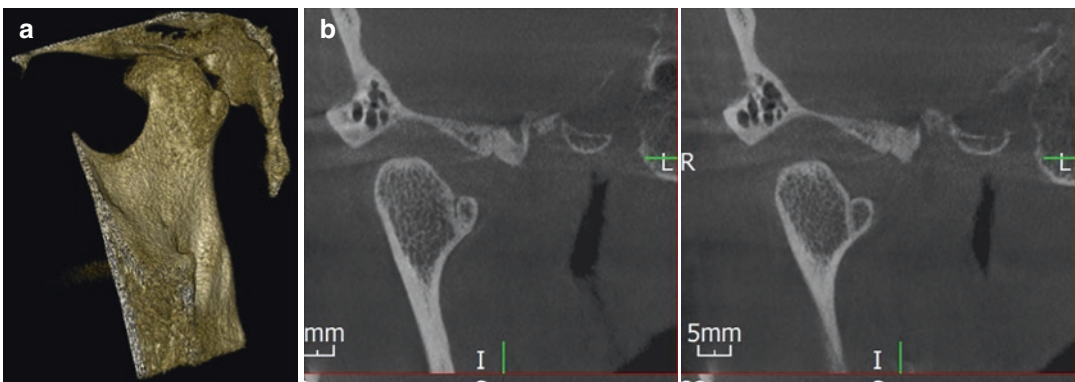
(a) 3D reconstructed CT image of Bifid condyle. (b) Coronal section of CT images showing bifid condyle
